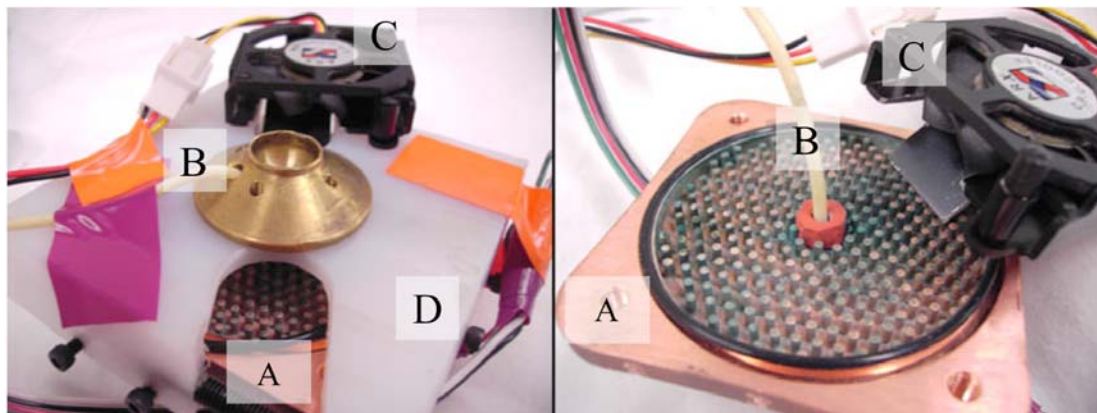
(A)Thermoelectric cooling system, (B) heat radiator, (C) TE cooler, (D) customized thermistor, and (E) Laser Doppler probe
